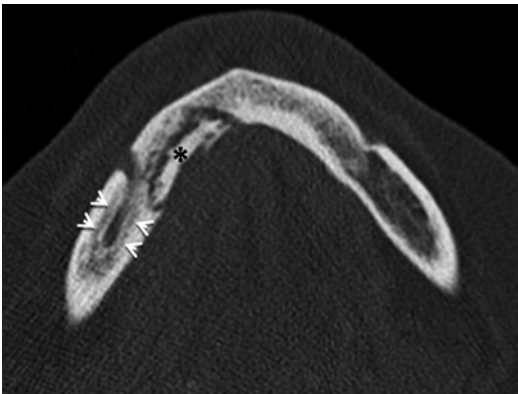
BRONJ in the right mandible. Multislice CT depicting a large lingual mandibular sequestration (*black asterisk*) and prominent mandibular canal (*white arrowheads*) as sclerosis affects the margins of the canal
